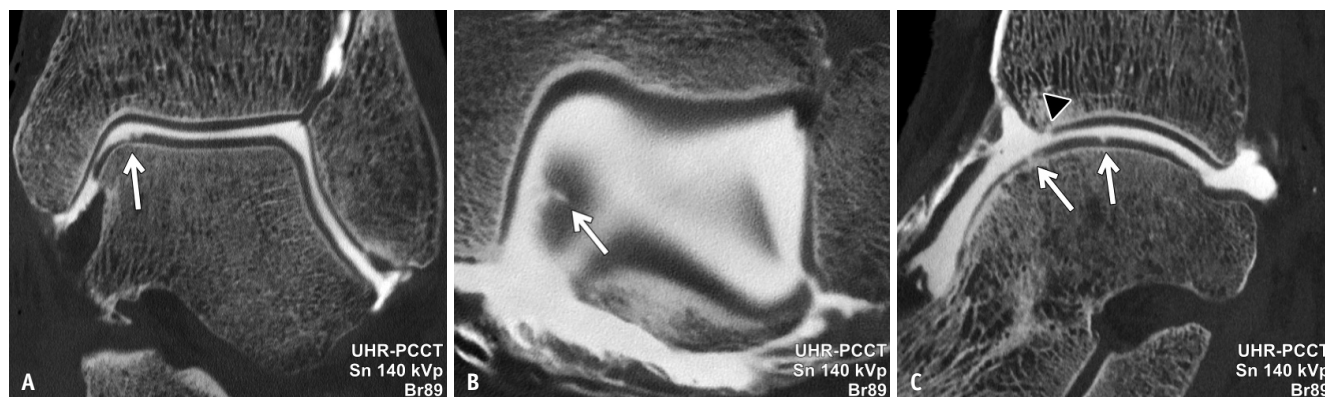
UHR-PCCT arthrography of the left ankle of a 58-year-old female. A-C: While the articular injection of iodine-based contrast agent aids the depiction of minute cartilage injuries of the talus bone (arrows) and distal tibia (arrowhead), the virtual subtraction of contrast material may be helpful when generating three-dimensional models for preoperative planning. UHR = ultra-high-resolution, PCCT = photon-counting computed tomography
